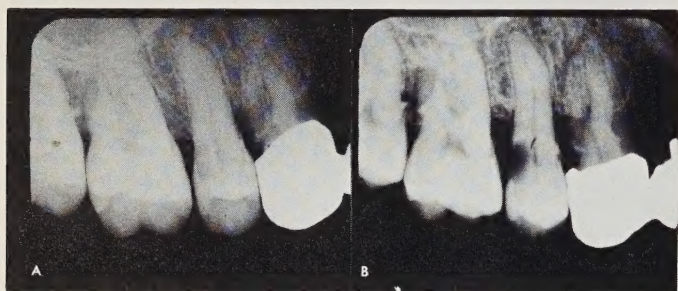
Patient referred to periodontist because of pain. A. Roentgenograph made by "bisect-the-angle" technique and 65 Kvp. shows evidence of periodontitis with no indication of the cause of pain. B. Roentgenograph made one hour later with 86 Kvp. and parallel projection shows image of cavity causing pulpitis. The cavity was easily located with a mouth mirror and explorer.†
